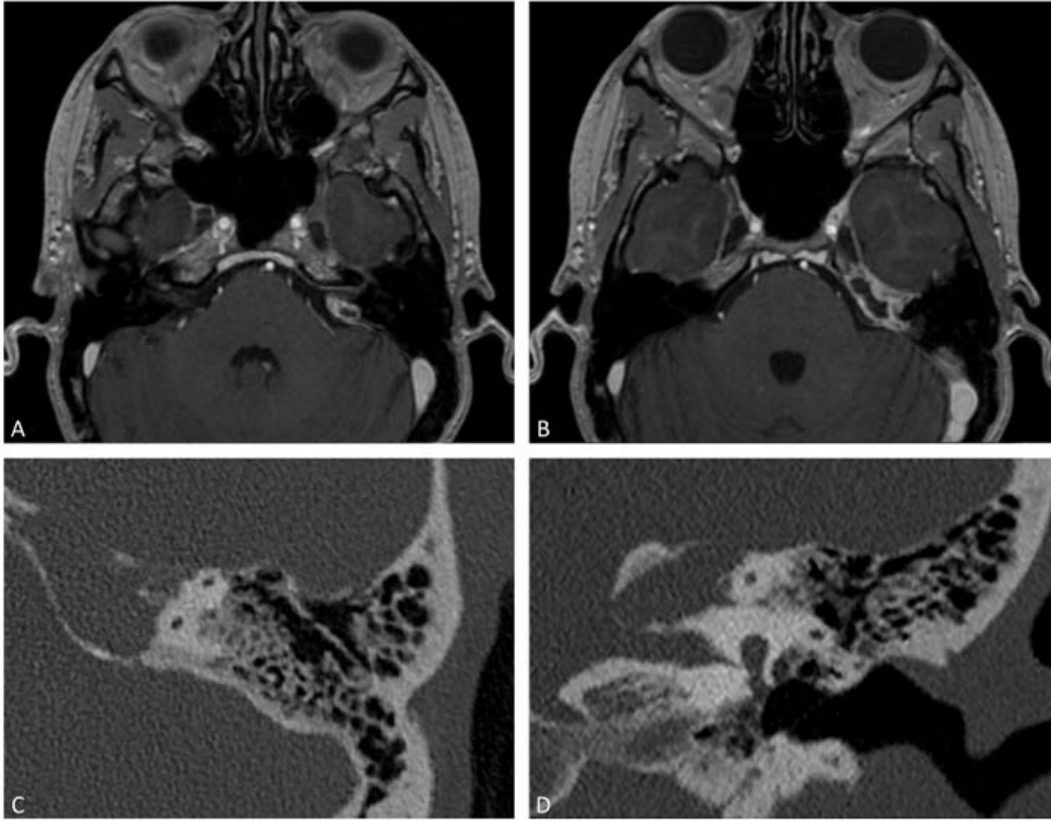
Contrast-enhanced inner auditory canal MRI, T1 sequence (A and B); and left temporal bone CT, axial (A) and coronal slice (B).
